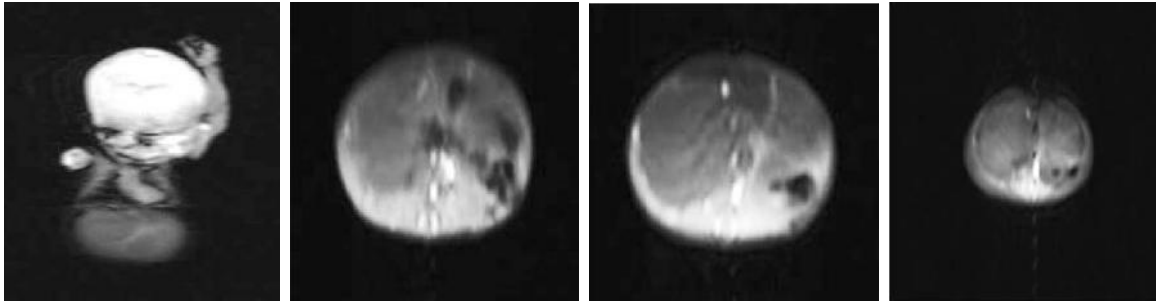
Second MRI in the age of 3-months with dominantly cystic hepatic mesenchymal hamartoma
